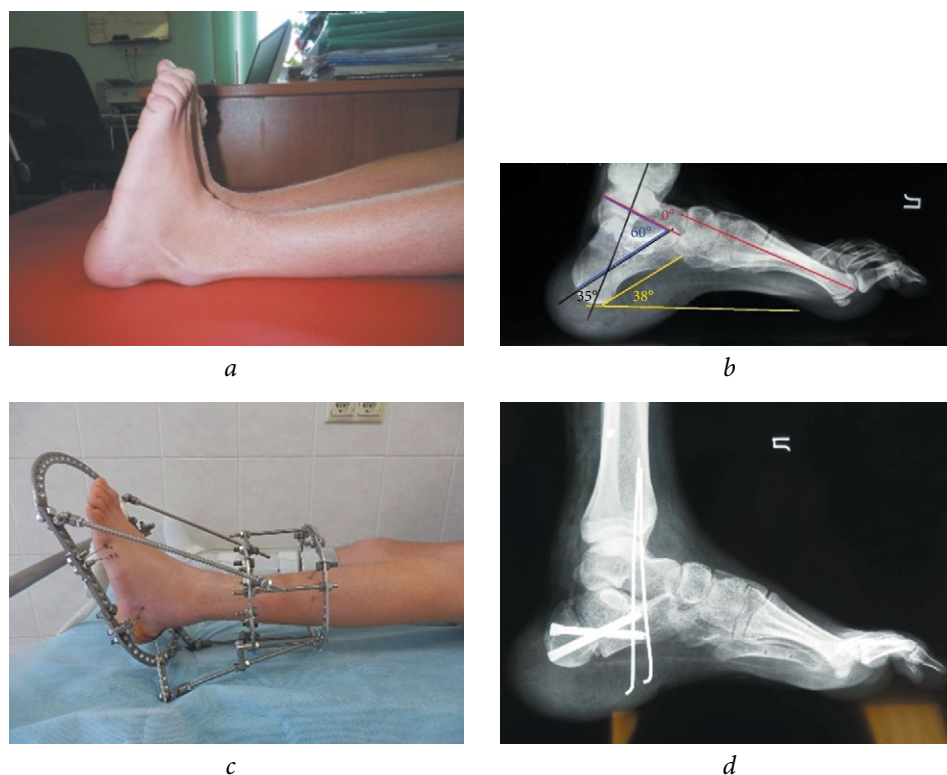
Patient A., 15 years old, with a diagnosis of meningomyeloradiculocoele of the lumbosacral spine. Neurogenic calcaneal deformity of the feet: *a* — the appearance of the feet upon admission; *b* — radiograph of the left foot in lateral projection upon admission; *c* — the appearance of the foot in the first stage of treatment in the Ilizarov apparatus, flexion of the foot of 20° is achieved; *d* — radiograph of the foot in lateral projection after surgical treatment
